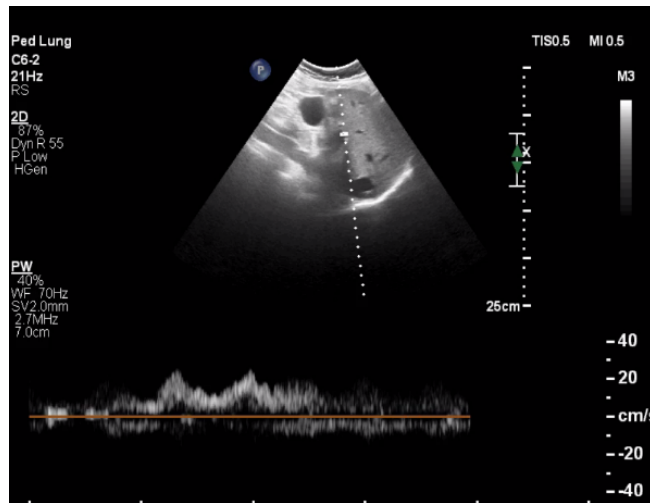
Portal vein Doppler waveform used for VExUS grading.
